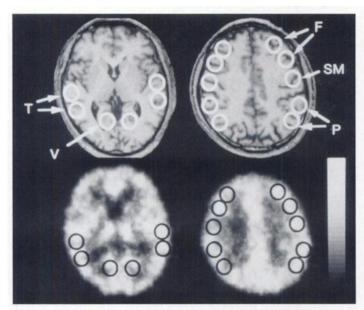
MR image and CBF image from a 54-yr-old healthy man with overlaid ROIs. T = temporal; V = visual; F = frontal; SM = sensorimotor; P = parietal cortex.
